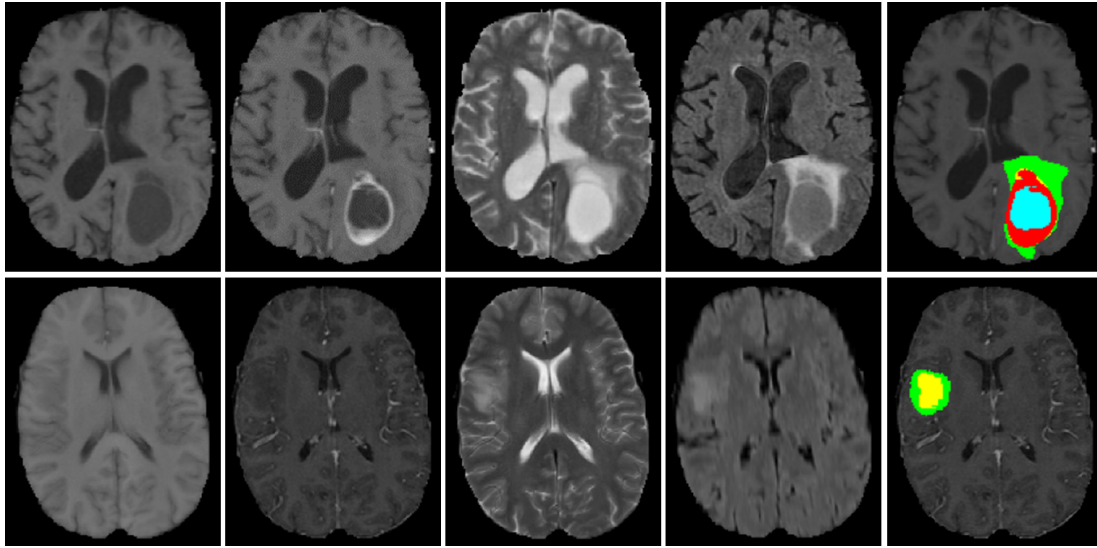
Examples of segmentations in the Leaderboard data set, showing a HGG in the first row (subject id: 210) and a LGG in the bottom row (subject id: 105). From left to right: T1, T1c, T2, FLAIR, and the segmentation. Each color represents a tumor class: green – edema, blue – necrosis, yellow – non-enhancing tumor, and red – enhancing tumor.
